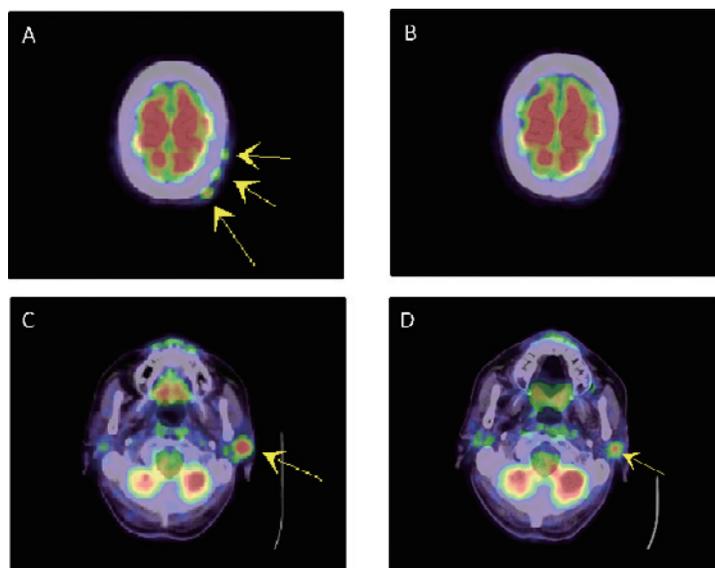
FDG-PET/CT before and after administration of nivolumab
